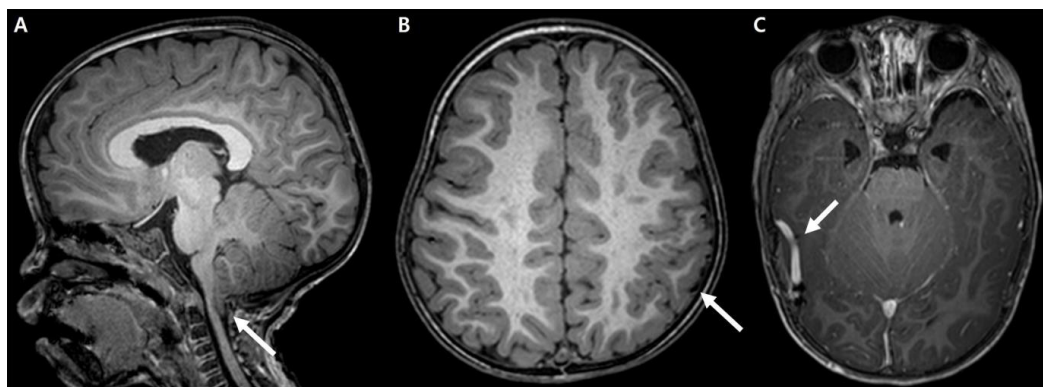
Cerebral magnetic resonance imaging findings for the patient. (A) Chiari I malformation with upper cervical cord compression (arrow). (B) Polymicrogyria (arrow) in the left frontoparietal lobe. (C) Prominent venous structures (arrow) on both cerebral convexities.
